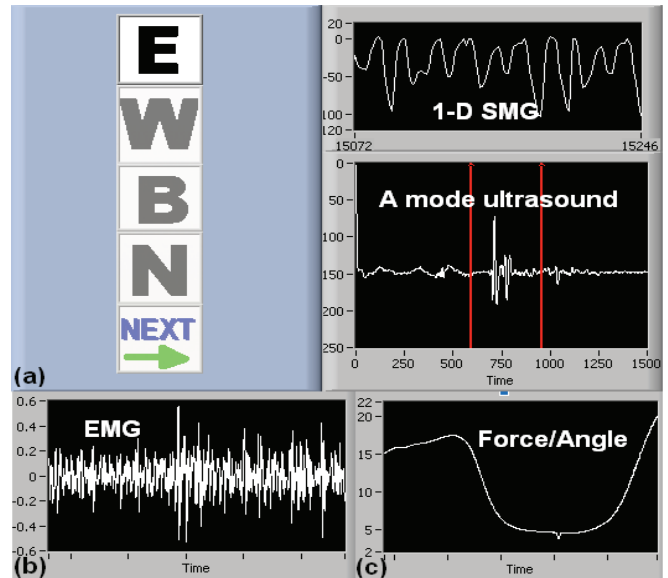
(a) The software interface used to collect 1-D SMG signals. The muscle deformation signal (i.e. SMG) extracted from A-mode ultrasound was displayed for controlling the cursor to cancel the letters. The muscle deformation was measured according to the echo movement reflected from the muscle-bone interfaces. Window was selected to include the ultrasound echoes. (b) The EMG signals were collected from the extensor carpi radialis muscle and EMG RMS was used to control the cursor. (c) The force collected from force sensor or angle detected by electrical goniometer was used to control the cursor.
